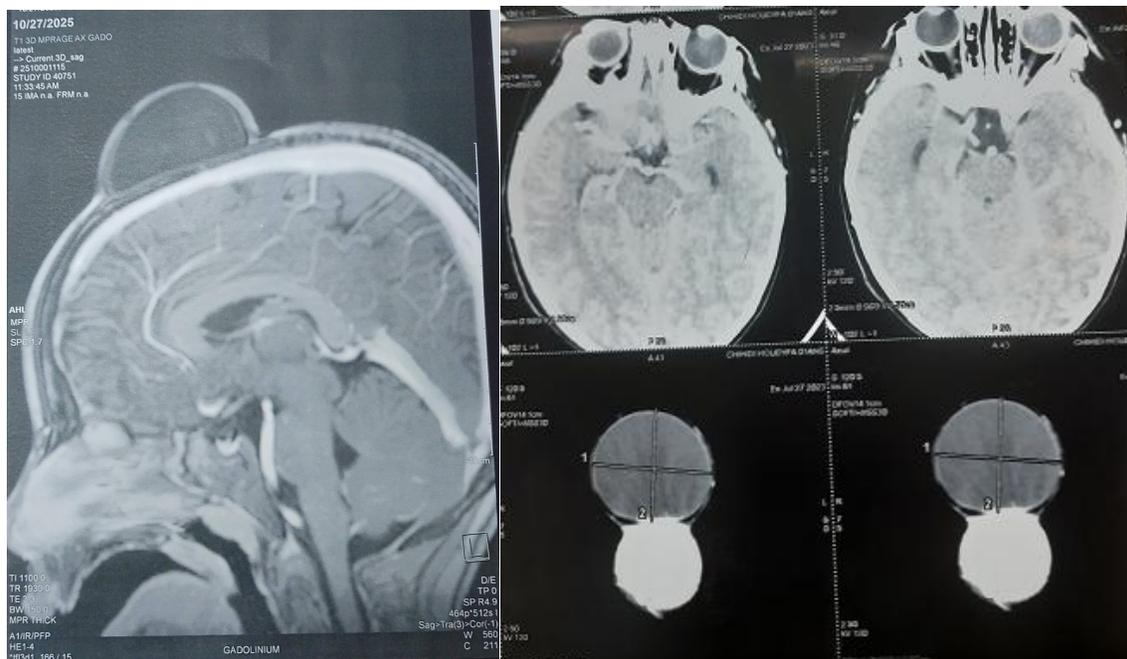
Contrast-enhanced brain MRI : midline anterior subgaleal cystic lesion measuring 49 × 26 × 52 mm, without enhancement and without intracranial communication; consistent with an anterior fontanelle inclusion cyst.
